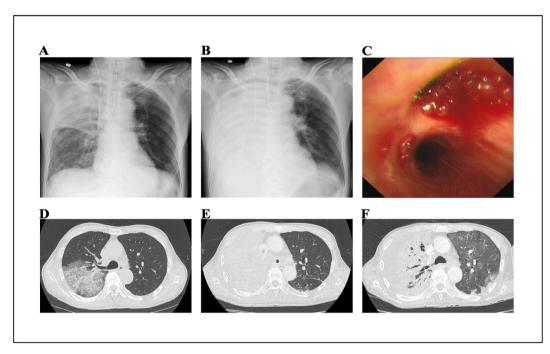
Radiographic and bronchoscopic findings.
